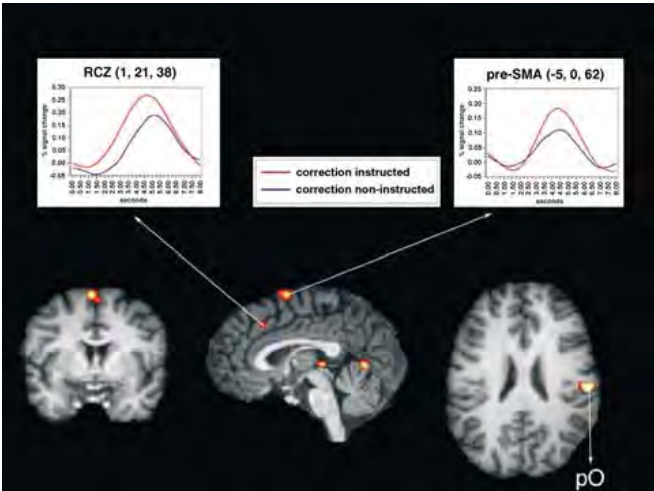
Cortical activations of the contrast of corrected erroneous trials vs. uncorrected erroneous trials on coronal ($y = 0$), sagittal ($x = -2$) and axial ($z = 24$) slices of a 3D structural MRI; activations in the cisterna cerebelli superior and in the cisterna laminae tecti were probably caused by pulsation artefacts; pO, parietal operculum. Top: trial averaged time courses of the two significantly activated areas on the frontomedian wall: superior pre-supplementary motor area (pre-SMA) ($x = -5$, $y = 0$, $z = 62$) and rostral cingulate zone (RCZ) ($x = 1$, $y = 21$, $z = 38$).
